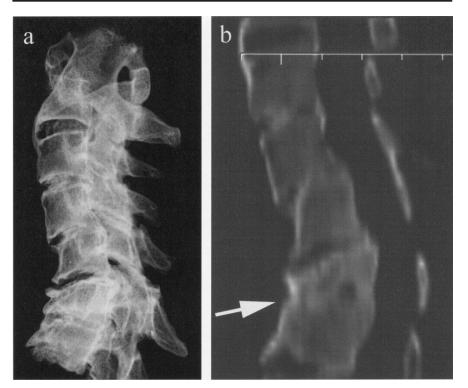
X-ray latero-lateral projection of the cervical column (a) and computed tomography showing osteolytic lesions in C6 (b).
